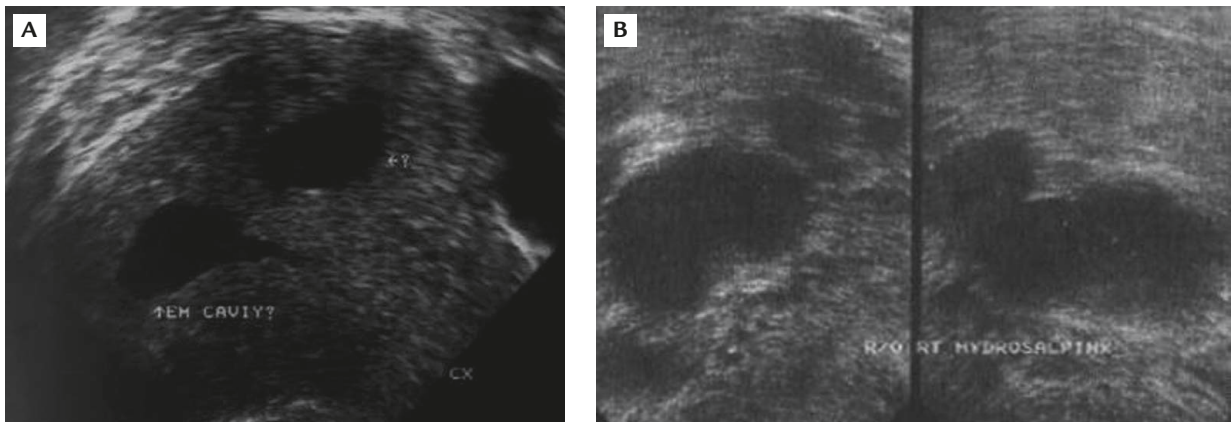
Transvaginal ultrasound shows: (A) irregular hypoechoogenic areas within the uterine cavity; (B) right fusiform anechoic adnexal mass. EM = endometrial.
